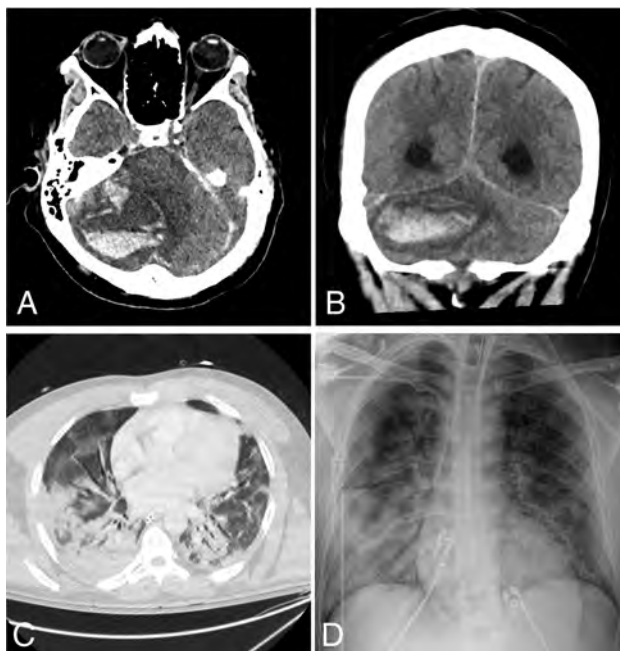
A 42-year-old man presented with hypoxemic respiratory failure. Non-contrast-enhanced axial (A) and coronal (B) CT head images demonstrate a new, large, right cerebellar intraparenchymal mixed-attenuation hematoma suggestive of hyperacute or active hemorrhage. C, Chest CT of the patient demonstrates bilateral consolidation and ground-glass opacities involving all lobes, with a CCS score of 18. D, Portable chest radiograph demonstrates bilateral patchy air space opacities with a PXS score of 10.3.
